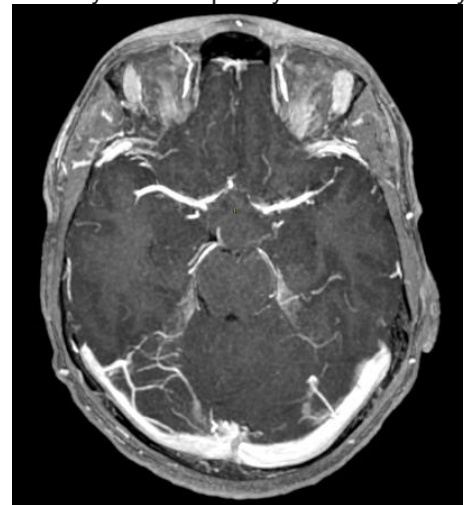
MRI image 3D T1 sequence after gadolinium injection showing venous thrombosis of the superior longitudinal sinus and the right lateral sinus
